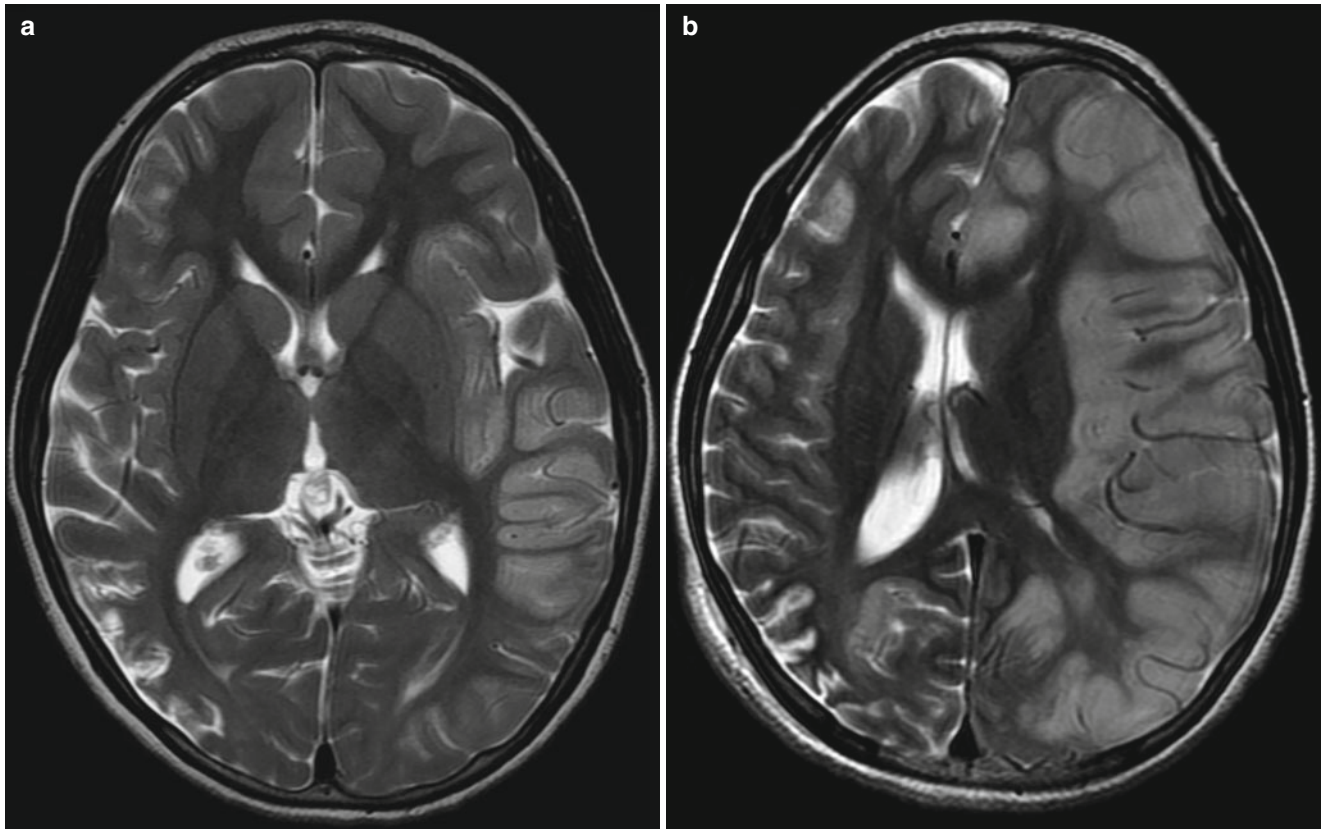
Citrullinemia in a 16-year-old boy with drowsiness, fever, and stroke-like symptoms. (a) T2-weighted image shows gyral swellings involving the left insula and temporo-occipital cortex. Serum ammonia level was elevated. (b) Follow-up image after 5 days shows
